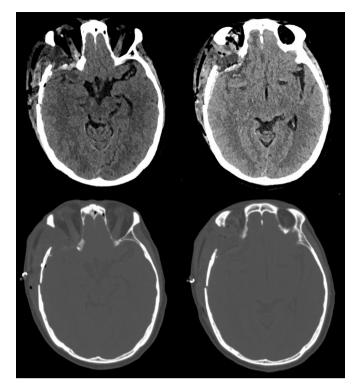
Postoperative CT confirmed gross total resection.
